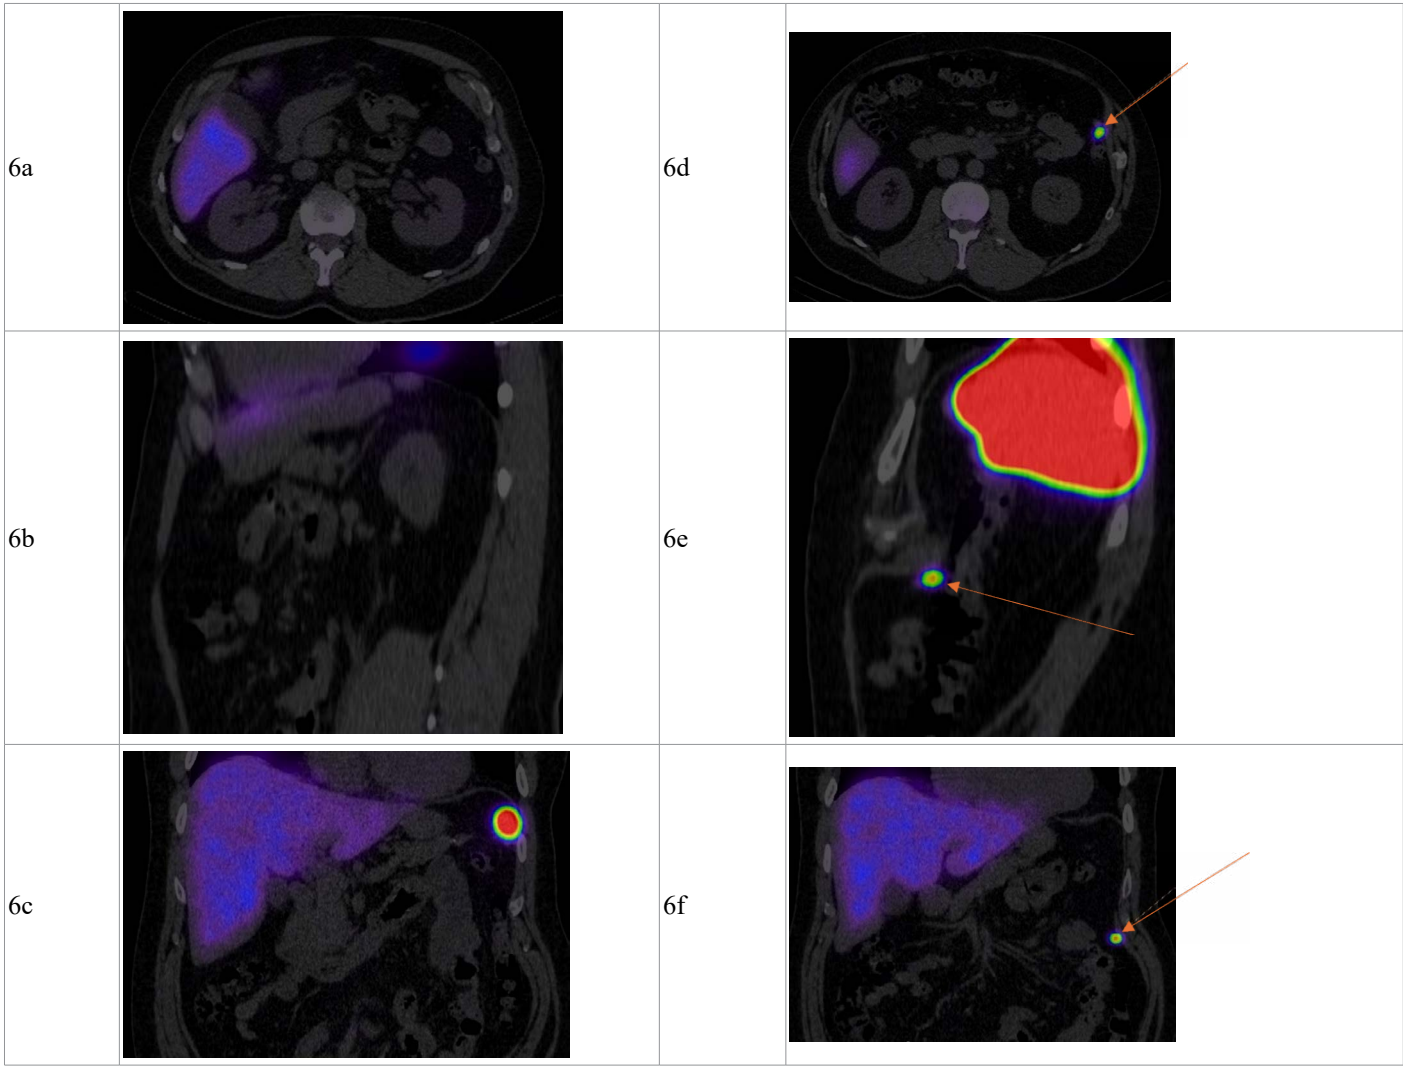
Tc-99m heat-damaged red blood cell (HDRBC) SPECT/CT confirming accessory splenic tissue in a left upper quadrant peritoneal nodule.
